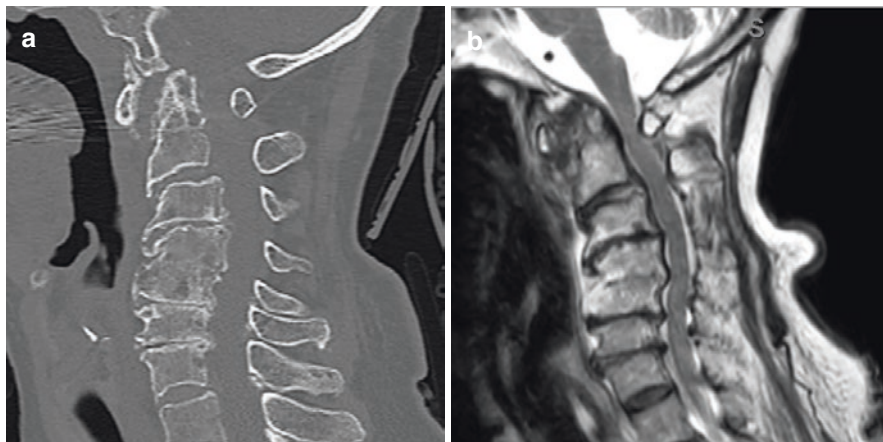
(a) Sagittal cervical spine CT showing anterior atlantoaxial subluxation with widened atlantodental interval to 6.5 mm and basilar invagination. (b) Sagittal T2 cervical spine MRI showing multilevel central stenosis with severe C1–2 stenosis
